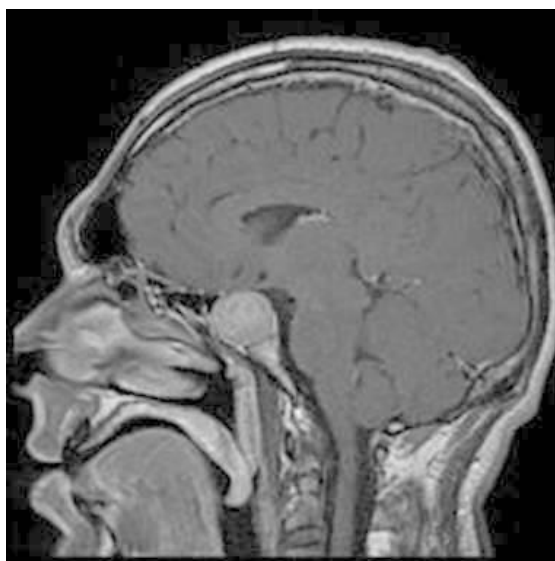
MRI image indicating a GH-secreting pituitary macroadenoma.
